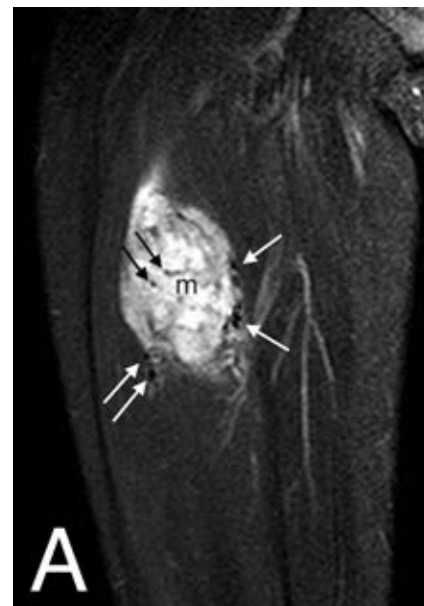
Coronal T2-weighted short tau inversion recovery magnetic resonance imaging (MRI) of the right thigh (A) shows a high signal intensity soft tissue mass (m), with prominent intra-tumoral flow voids (black arrows) and peri-tumoral flow voids (white arrows), reflecting hypervascularity. On axial T1-weighted MRI (B), the anterior compartment mass (m) is mildly hyperintense to adjacent musculature. On axial gadolinium-enhanced T1-weighted MRI with fat suppression (C), the mass (m) and its feeding vessels (arrows) enhance vigorously.
